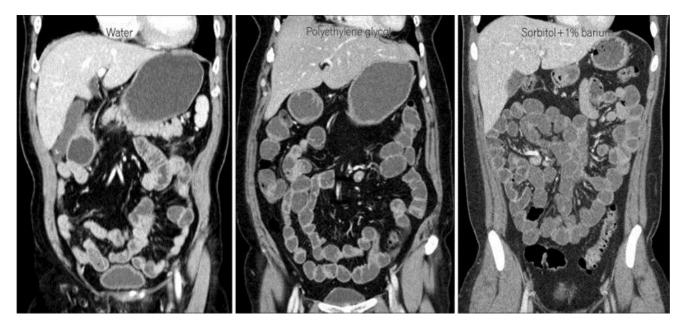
Many neutral enteric contrast agents were utilized. CT enterography using polyethylene glycol (in the middle image) as well as sorbitol (in the right image) that extends through small bowel, while at the CT enterography utilizing the water (in the left image) that extends through the small-bowel loop suboptimally ⁽¹⁵⁾.
